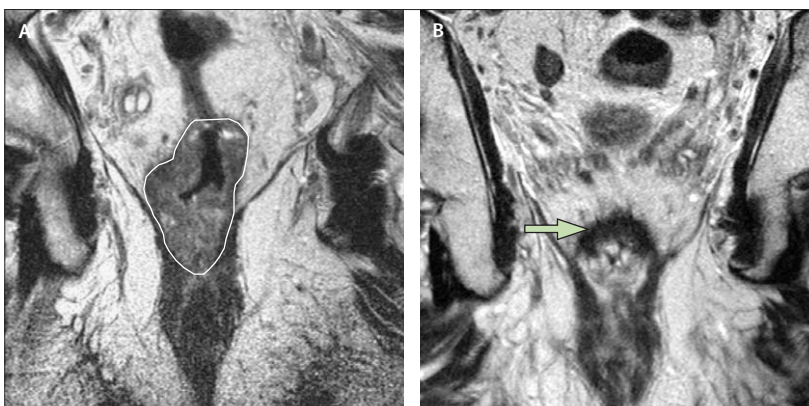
Coronal T2-weighted MRI of T3 tumour
